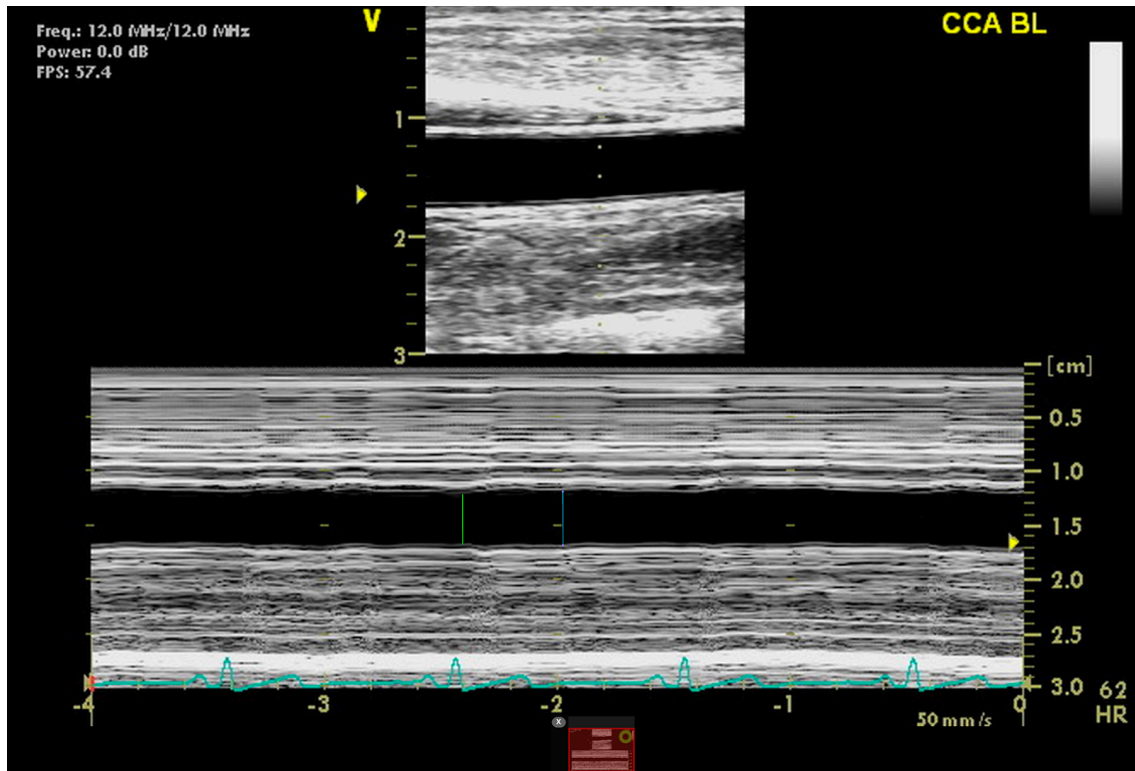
Depiction of Vivid I ultrasonography recording a baseline image of the brachial artery (Pulse-wave and M-mode).
